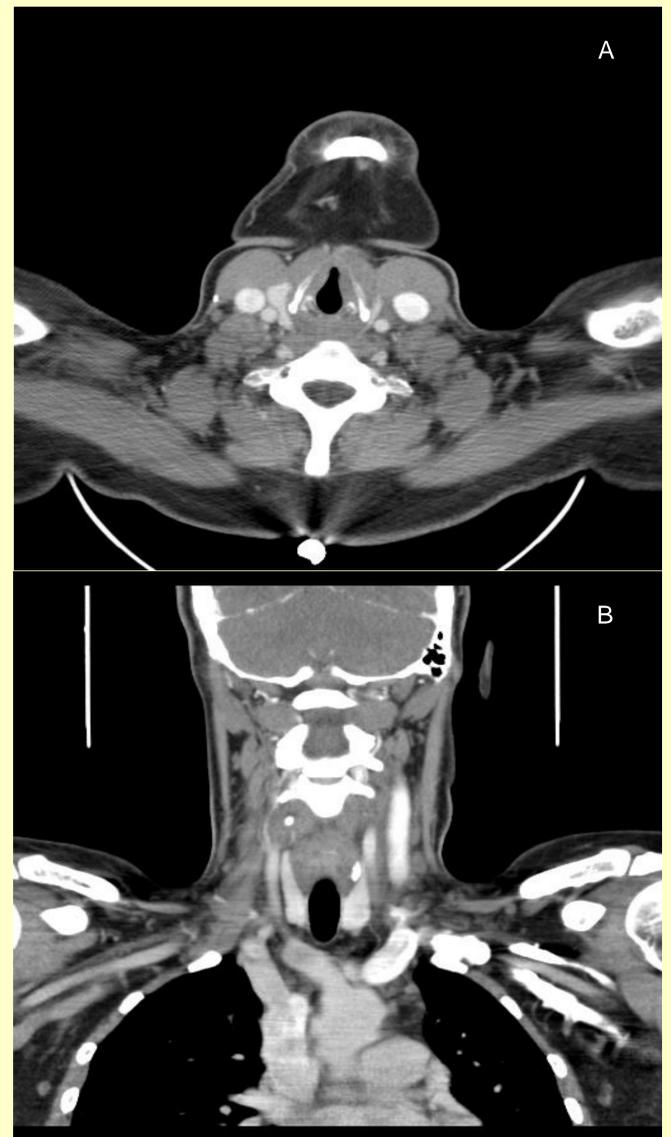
Computed tomographic scan of the neck with contrast in axial (A) and coronal (B) views showing separation of the left internal jugular vein and common carotid artery at the level of the thyroid cartilage consistent with edema and inflammation of the carotid sheath.
